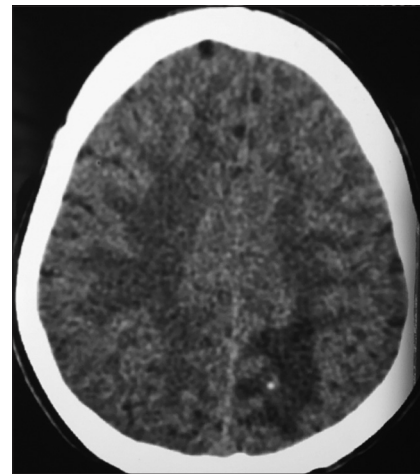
Computed tomography brain showing left parietal granuloma with perilesional edema
